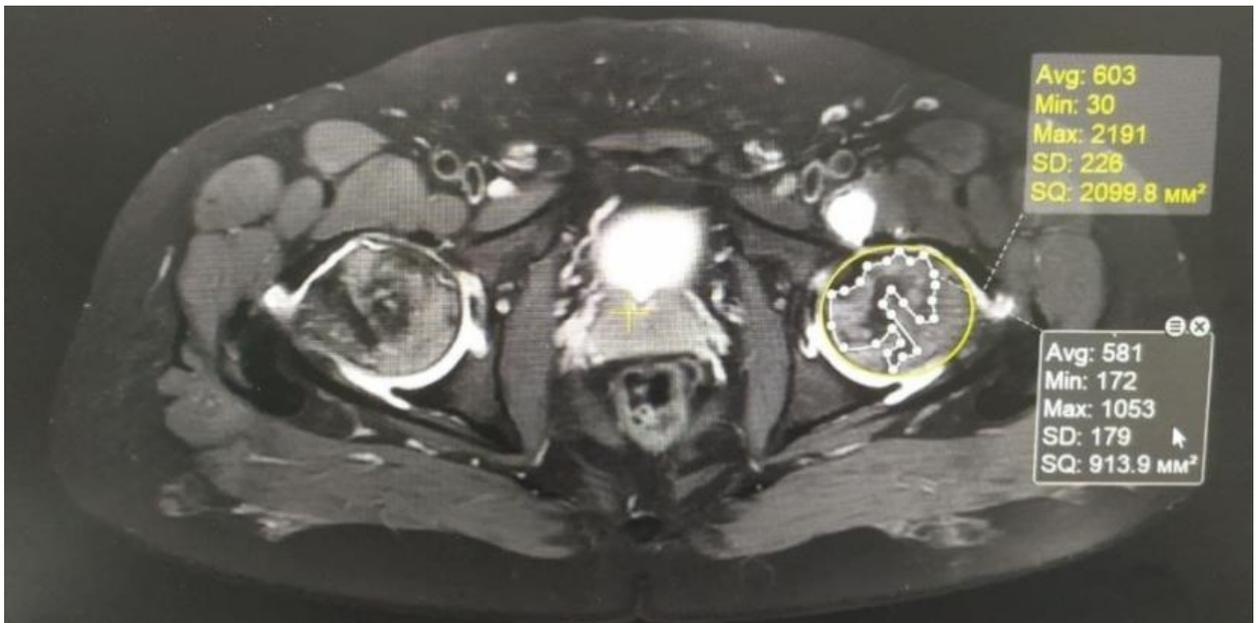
MRI of patient I.O. 1978 No. IB 3761/431 with stage II of the disease ANFH 6 months after denervation.
